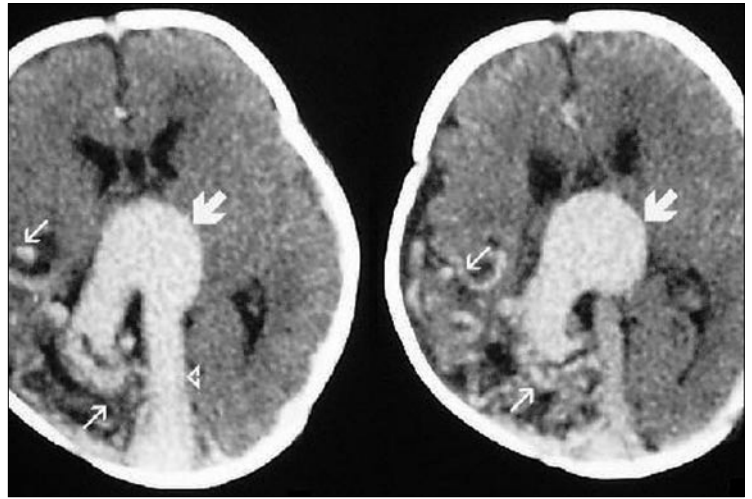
Sequential postnatal contrast-enhanced CT images demonstrate right parietooccipital lobe arteriovenous fistula (*thin arrows*) draining into the vein of Galen, the dilatation of the vein of Galen (*thick arrows*), the straight sinus (*arrow head*), right parietooccipital atrophy, and ischemia.
